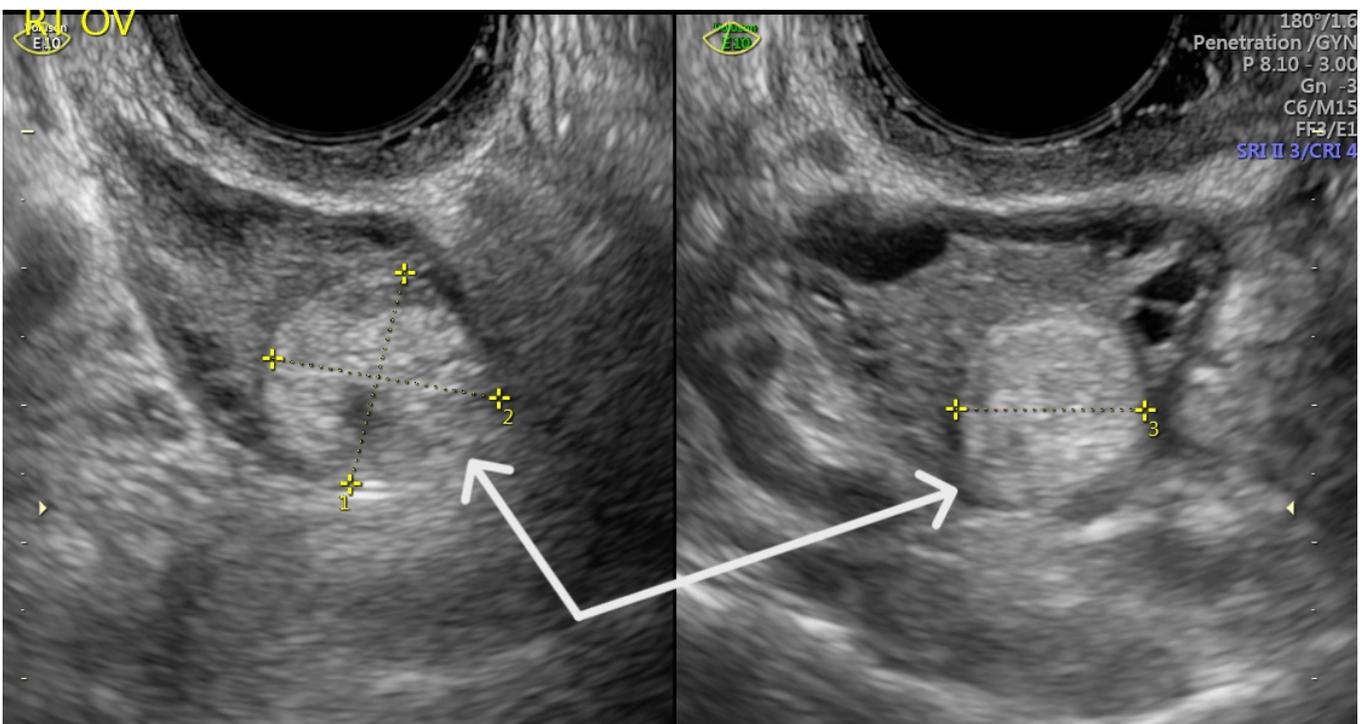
Transvaginal ultrasound showing a right ovarian echogenic complex mass (white arrows) that measures 1.7 x 1.6 x 1.3 cm.
